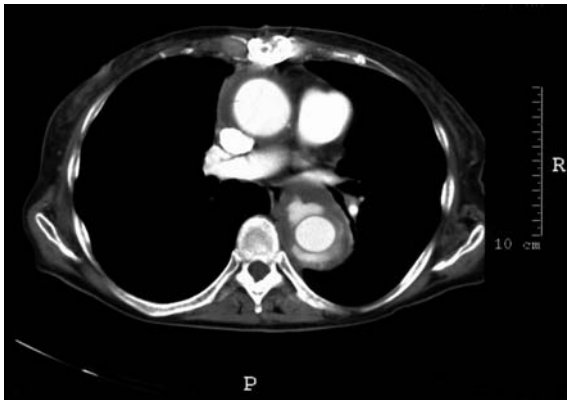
Computed tomography of the chest after total arch replacement with an elephant trunk. The graft extension can be seen easily; there is the beginning of thrombosis of the aortic lumen around the trunk
